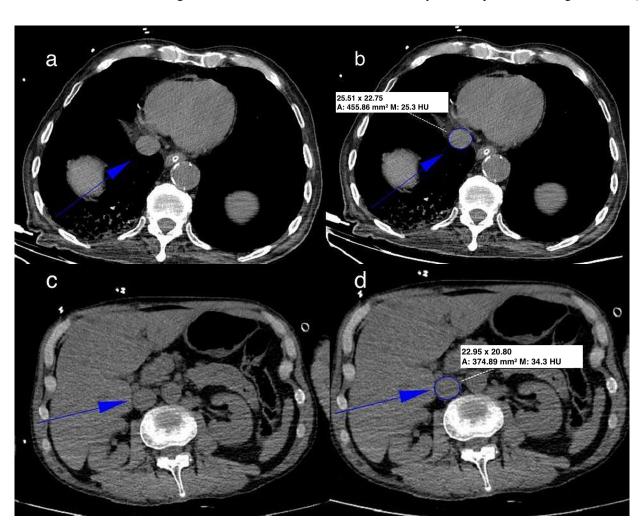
Computed tomography measurement examples of the inferior vena cava. Description: Measurement techniques for the Inferior Vena Cava (IVC) on coronal Computed Tomography (CT) images. (a) The upper measurement point of the IVC at the eighth thoracic vertebra (T8) level is indicated by a blue arrow. (b) Corresponding automated measurement results for the upper section. The parameters shown include the area (A), defined as the cross-sectional area (CSA; mm²), and the mean attenuation (M) in Hounsfield Units (HU). (c) The lower measurement point of the IVC at the tenth thoracic vertebra (T10) level. (d) Corresponding automated measurement results for the lower section. These CT-based measurements provide objective data on IVC lumen size and density at two distinct thoracic levels.
